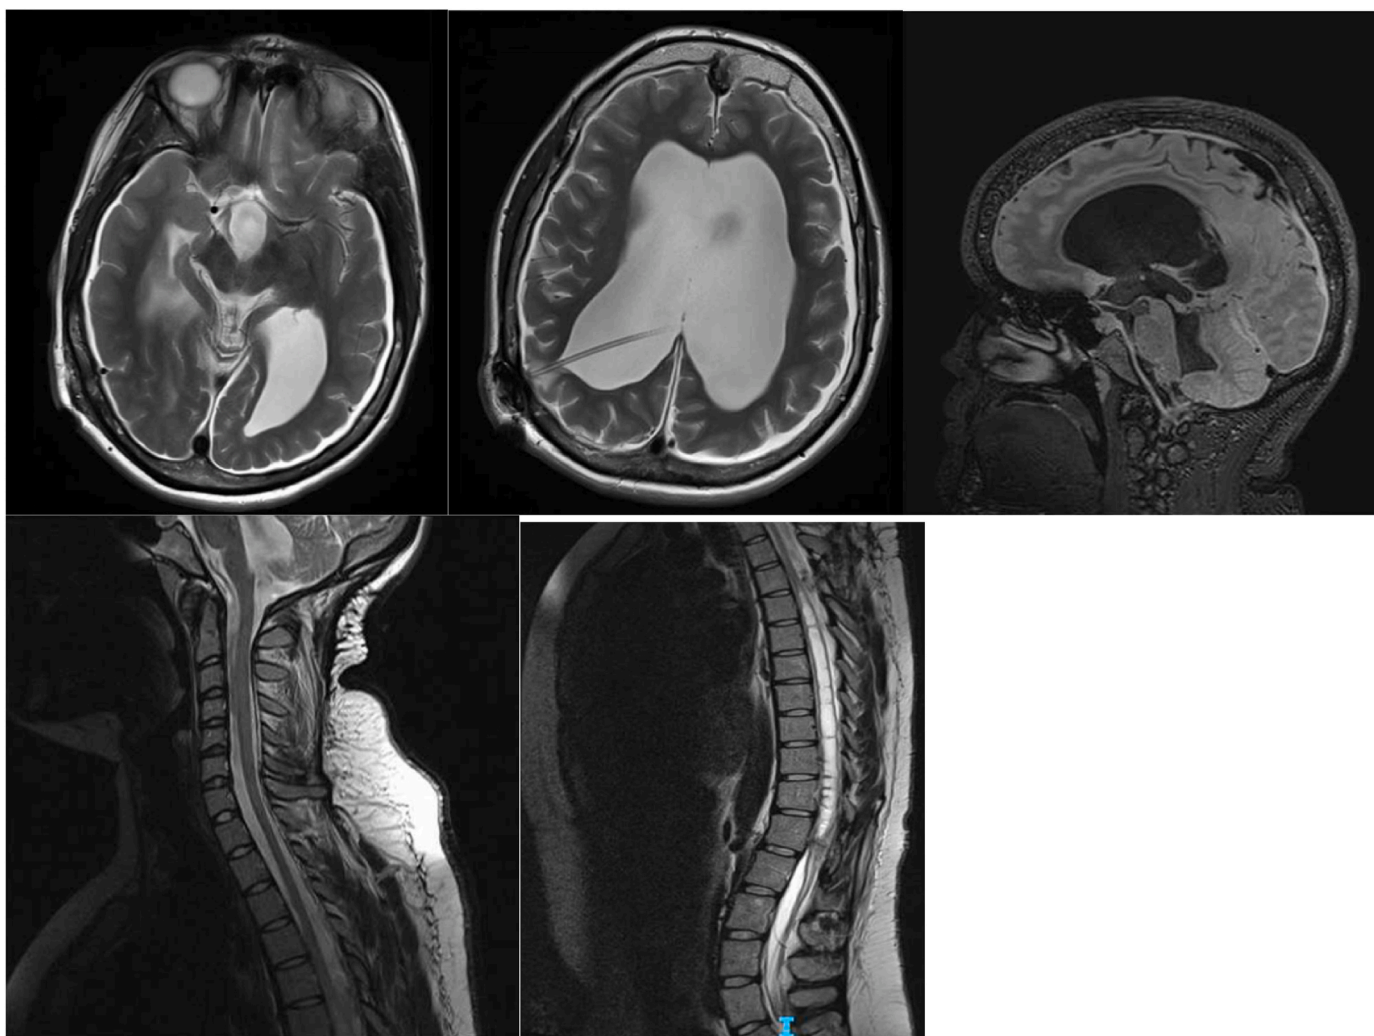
T2 and FLAIR MRI images of the brain and spinal cord prior to theophylline.
